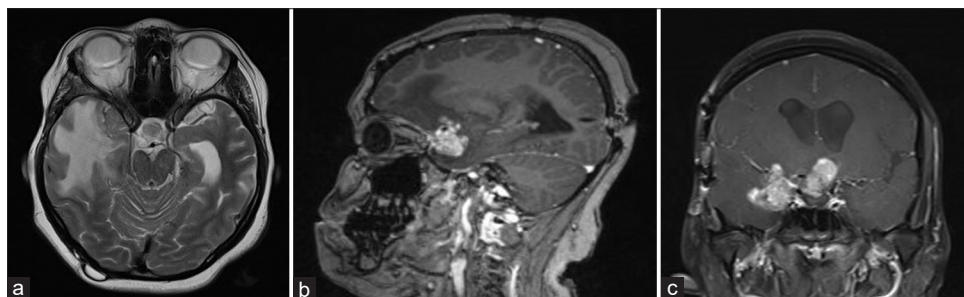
Axial magnetic resonance imaging (MRI) T2 (a) and sagittal MRI T1 with contrast (b) and coronal MRI T1 with contrast (c) demonstrating a lesion recurrence in the suprasellar region with new extension to the right middle cranial fossa and surrounding right temporal vasogenic edema is noted. Occipital VP shunt is visible on the sagittal image.
